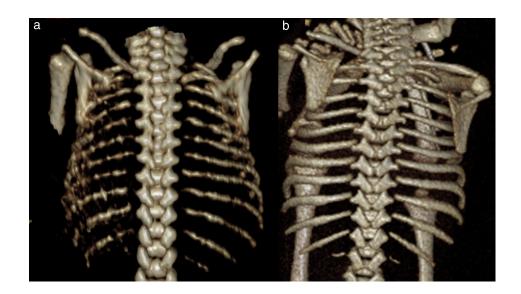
Subtle signs of congenital hypotonia on computed tomography: thin ribs. (a) Thin ribs detected prenatally in late third trimester in case of myotonic dystrophy. (b) Normal fetal ribs demonstrated in late third trimester in case of Prader–Willi syndrome.
